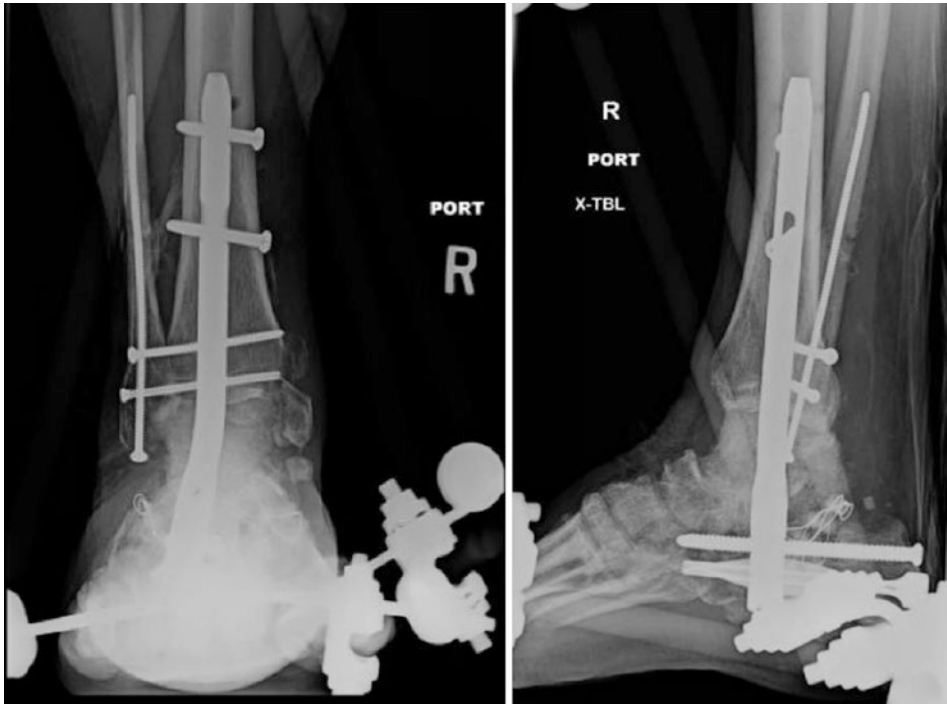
Immediate postoperative AP and lateral X-rays after delayed bone grafting (autograft bone harvested using RIA combined with allograft), 3 months from initial injury
